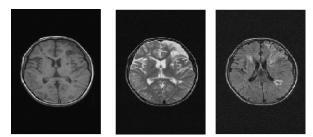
MRI brain axial T1WS, T2WS & FLAIR sequences.
